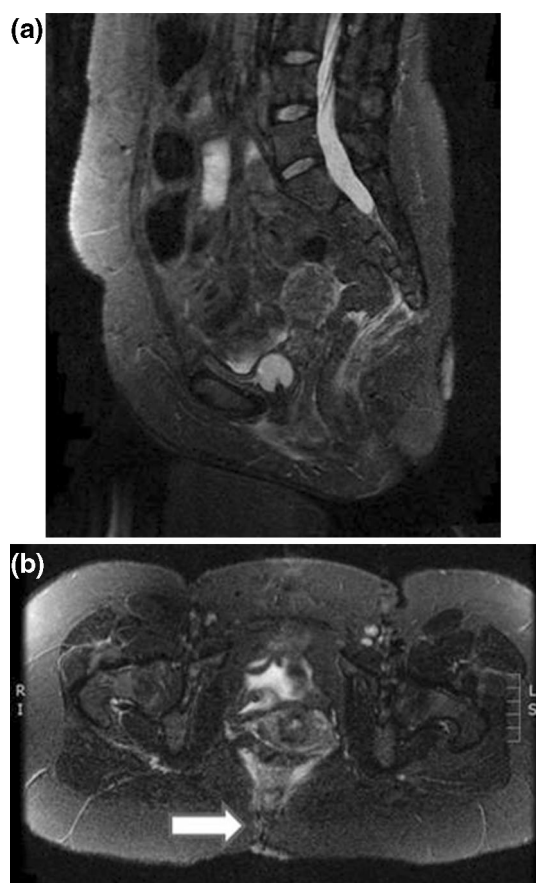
A sagittal (a) and transverse (b) MRI views of the spine and pelvis taken at presentation, showing a sinus track and soft tissue edema
